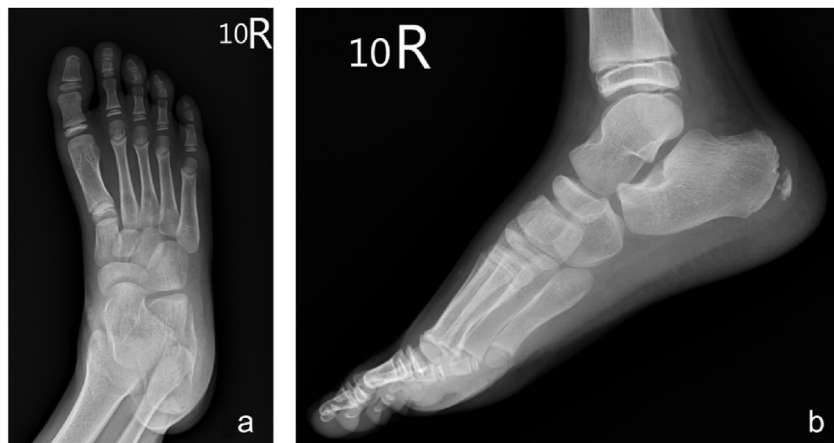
Initial radiography of a 10-year-old boy with progressive right ankle swelling and pain. Both (a) anteroposterior and (b) lateral views were reported as revealing a normal anatomical structure by the radiologist.
